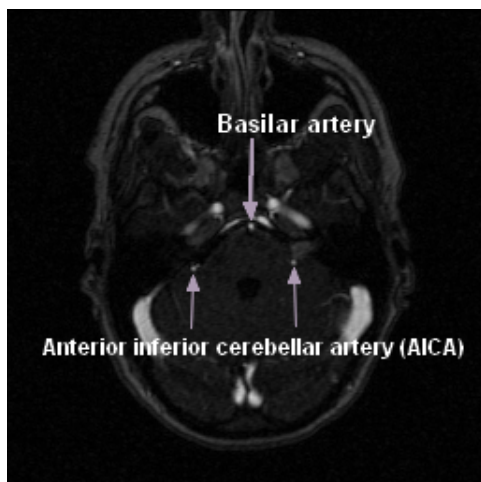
Anterior Inferior Cerebellar Artery (AICA) used for arterial input function determination in DCE-MRI pharmaco-kinetic modeling.
